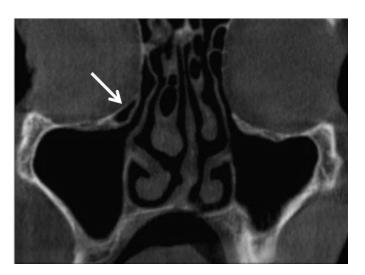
Coronal cone beam CT at Paranasal sinus level shows radiolucent, well corticated Haller cell on left side (arrow)
